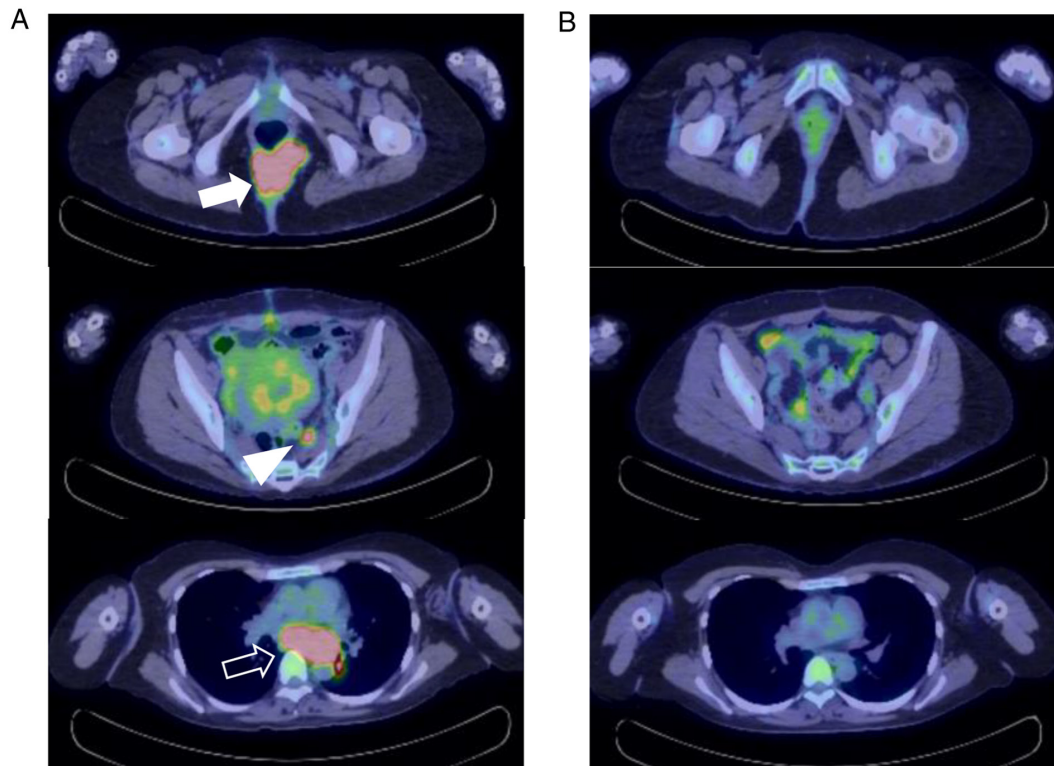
PET/CT findings. (A) Results at postoperative day 8. (B) Results after combination therapy with nivolumab and ipilimumab. (A) On postoperative day 8, FDG accumulation was identified in the buttock tumor, the main lesion (white arrow; upper panel), the myometrium and sacral lymph nodes (white arrowhead; middle panel) and in the mediastinal lymph nodes (black arrow; lower panel). (B) Postpartum nivolumab-ipilimumab combination therapy was highly effective, and abnormal FDG accumulation disappeared. FDG, fluorodeoxyglucose.
